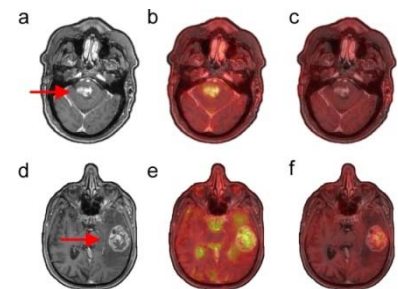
Exemplary T1w GAD+ (a, d), NaT (b, e) and NaR (c, f) data of a Pilocytic Astrocytoma (PA, WHO 1, a-c) and a Glioblastoma (GBM, WHO 4, d-f) demonstrate the benefit of ²³Na-MRI: In contrast to T1w GAD+ imaging, the ²³NaR contrast enables a distinction between PA (low signal, c) and its main differential diagnosis of a high grade glioma (high signal, f).
